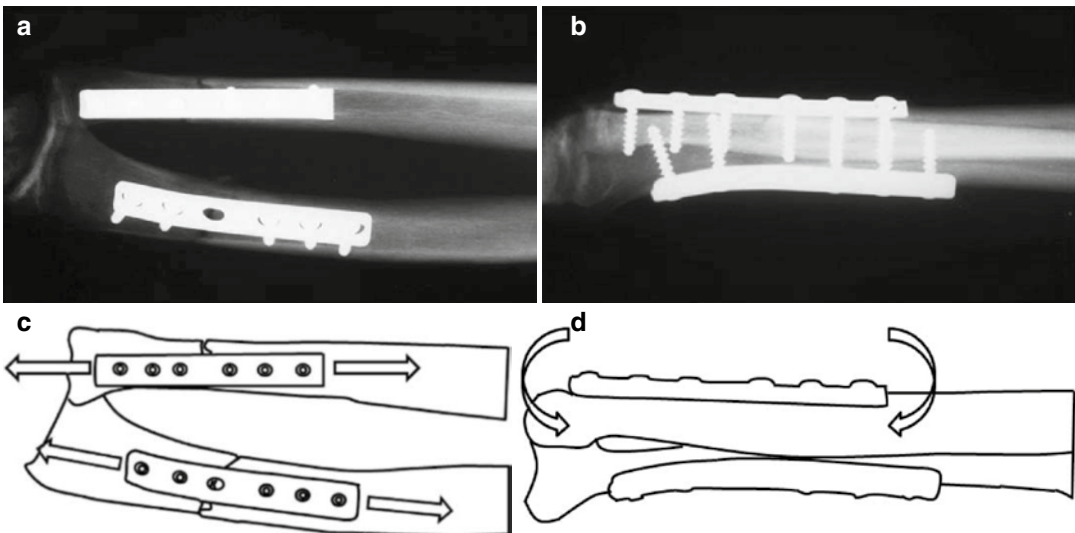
(a–b) Radiography of internal fixation plates on forearm fractures of the radius and ulna. The plates are load-bearing constructs and must withstand (c) tension and (d) bending forces until fracture healing is complete
